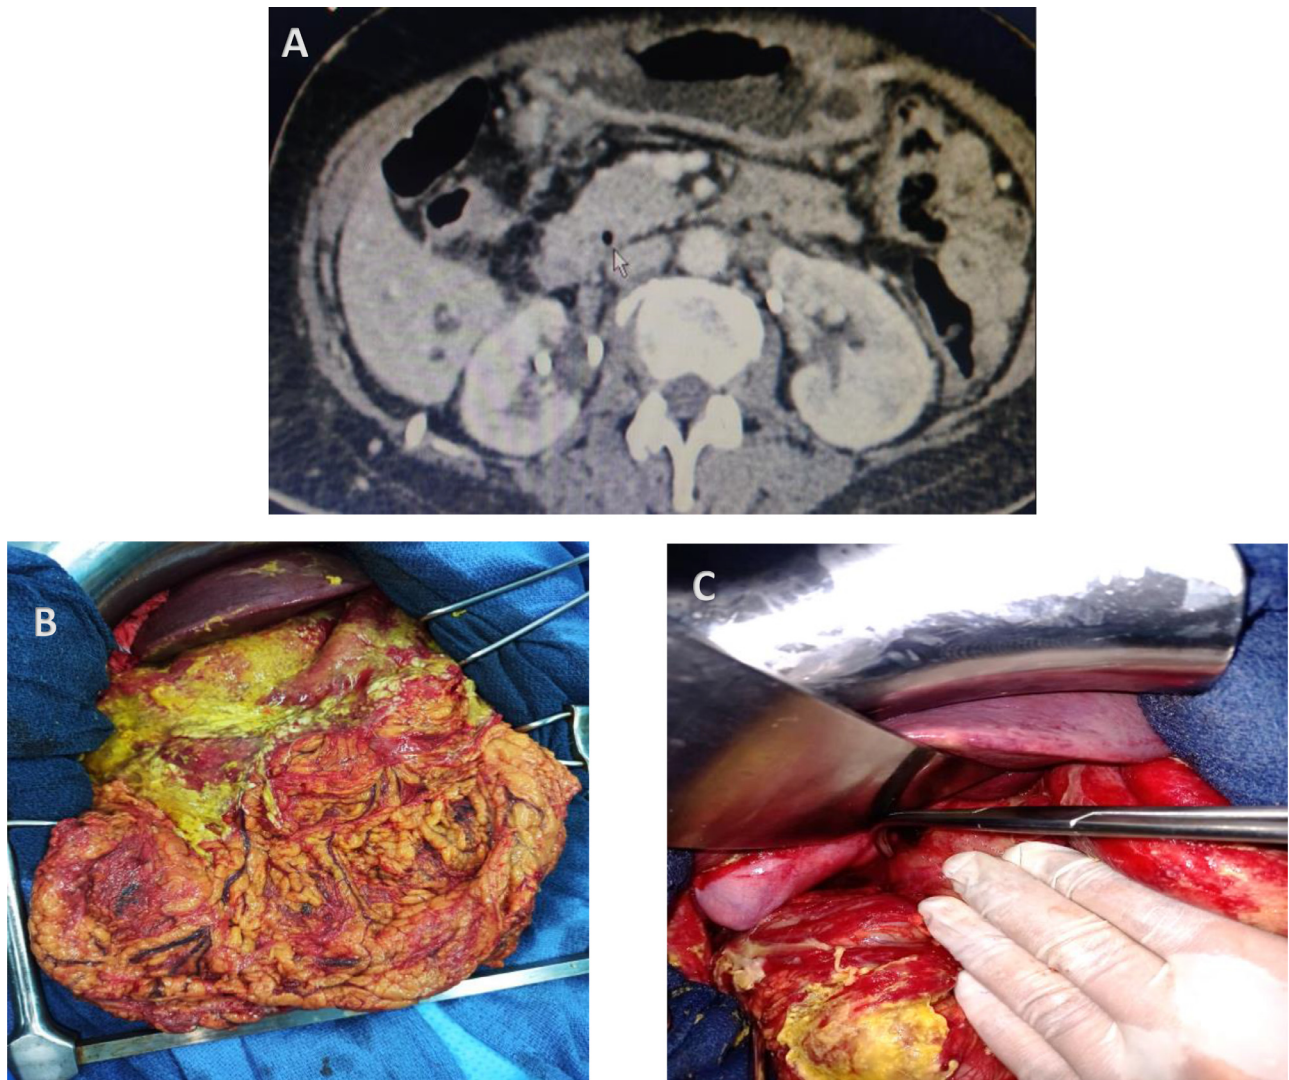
Perforation of gastroduodenal tumor; (A) Abdominal CT scan revealing a perforated gastroduodenal. tumor (arrow). (B) Purulent general peritonitis after an exploratory laparotomy. (C) Exploratory laparotomy showing a perforation in the second part of duodenum.
